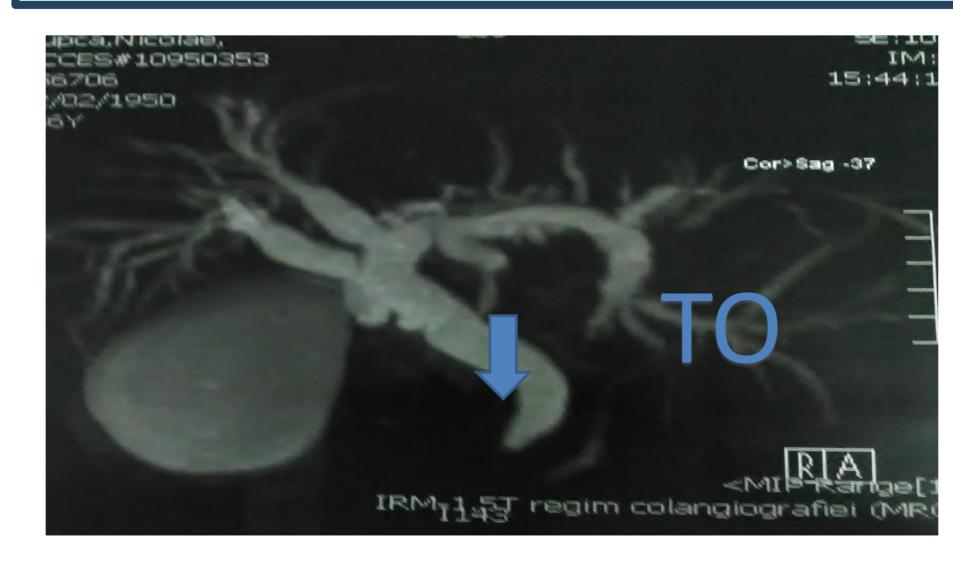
MRI COLANGIOGRAPHY in the diagnosis of acute biliary pancreatitis associated with jaundice
